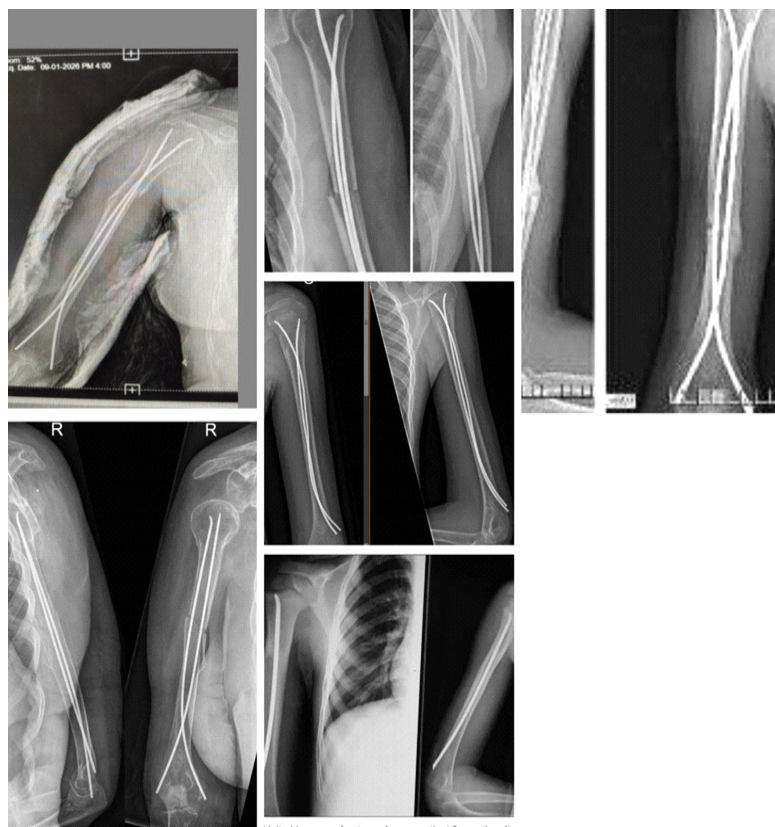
Representative radiographs from Cases 6–10 demonstrating fracture patterns and titanium elastic nailing system fixation.
